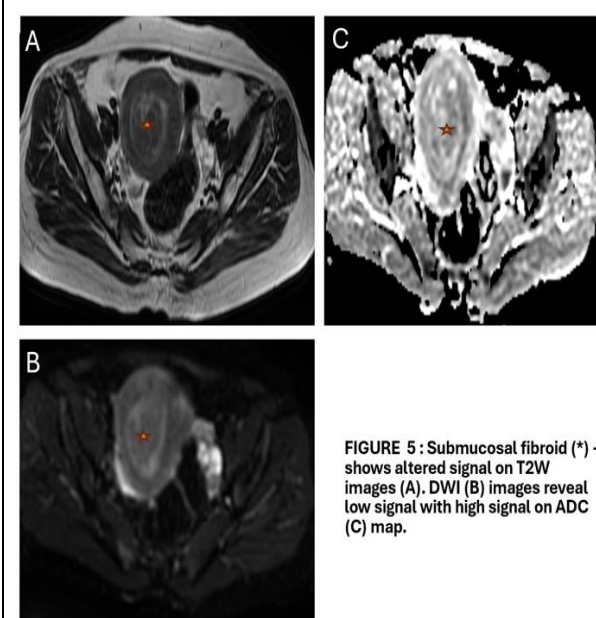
Submucosal fibroid (*) - shows altered signal on T2W images (A). DWI (B) images reveal low signal with high signal on ADC (C) map.
